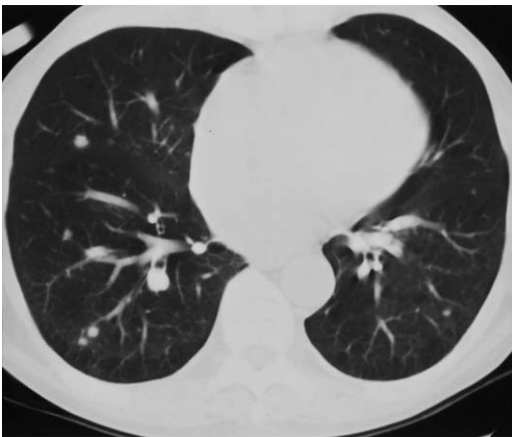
A 62-year-old man 1 year status post heart and liver transplant for amyloidosis. CT scan shows bilateral pulmonary nodules. Biopsy of the right lower lobe showed posttransplant lymphoproliferative disorder with features of large cell lymphoma.
